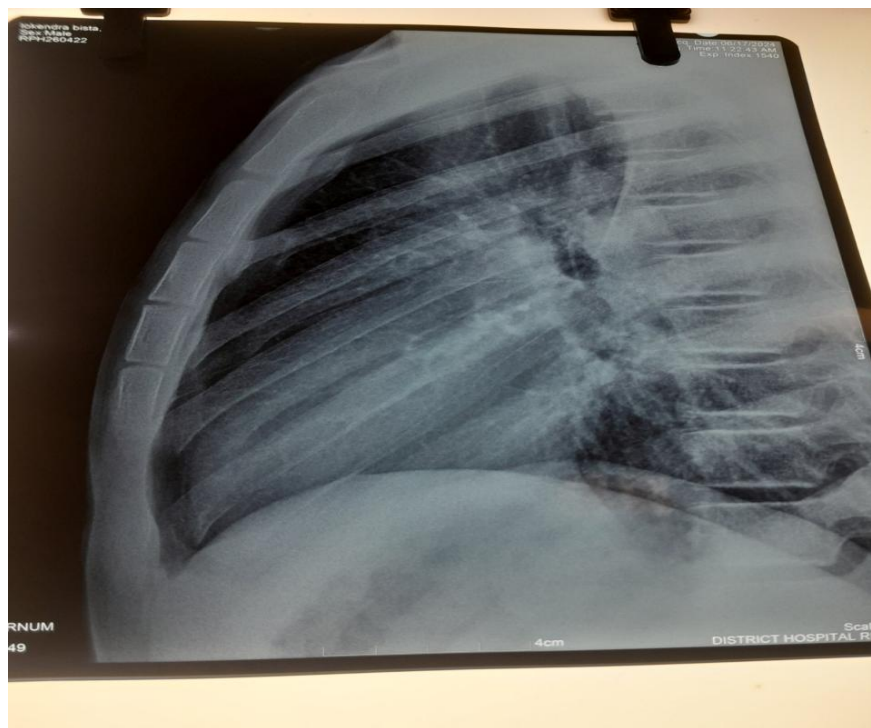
Xray sternum lateral at 5 weeks (absence of periosteal reaction)
